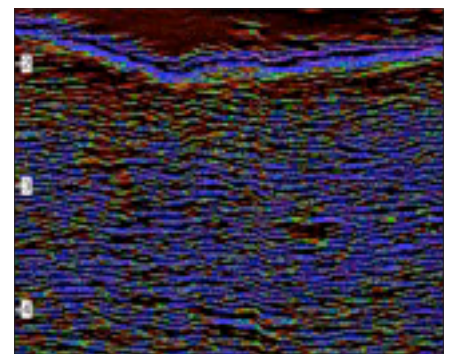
High-definition ultrasound scan showing reduction in red pixels and increase in blue pixels compared to Figure 4, indicating a reduction in oedema.
